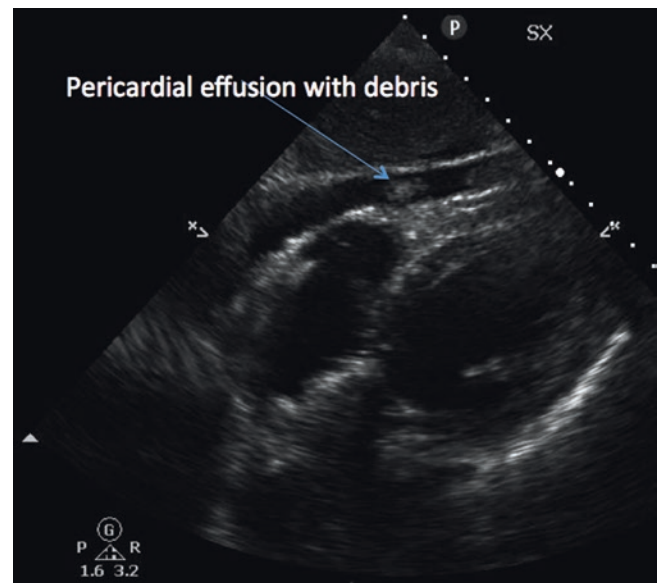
Cardiac ultrasound for pericardial effusion. A point-of-care echocardiography shows a pericardial effusion (echo-free space surrounding the heart) with fibrinous debris in a middle age patient with end stage renal disease admitted with fever and chest pain. The patient was diagnosed with uremic pericarditis which resolved with dialysis. See also Video 37.10
